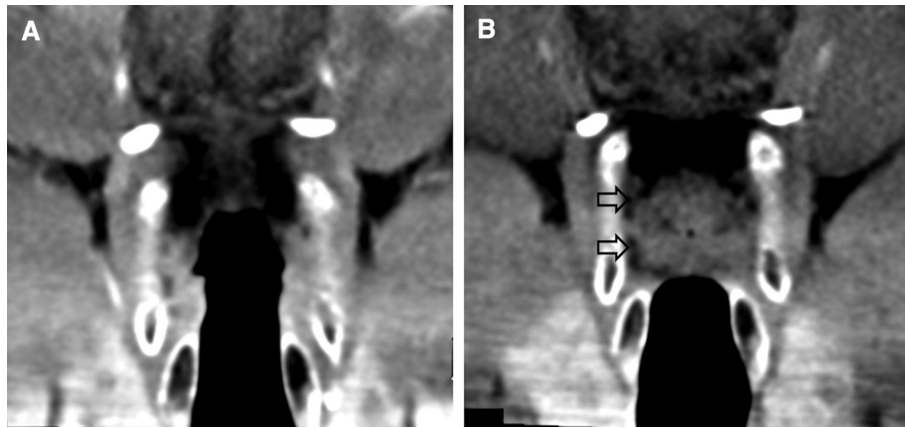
Coronal reformatted computed tomography (CT) images in a patient with right-sided vocal cord tumour, which is diagnosed endoscopically. (A) Inspiratory phase CT is not enabling clear visualization of the mass. (B) Valsalva phase CT, however, reveals the intact paraglottic fat planes as a thin hypodense line (open arrows).
